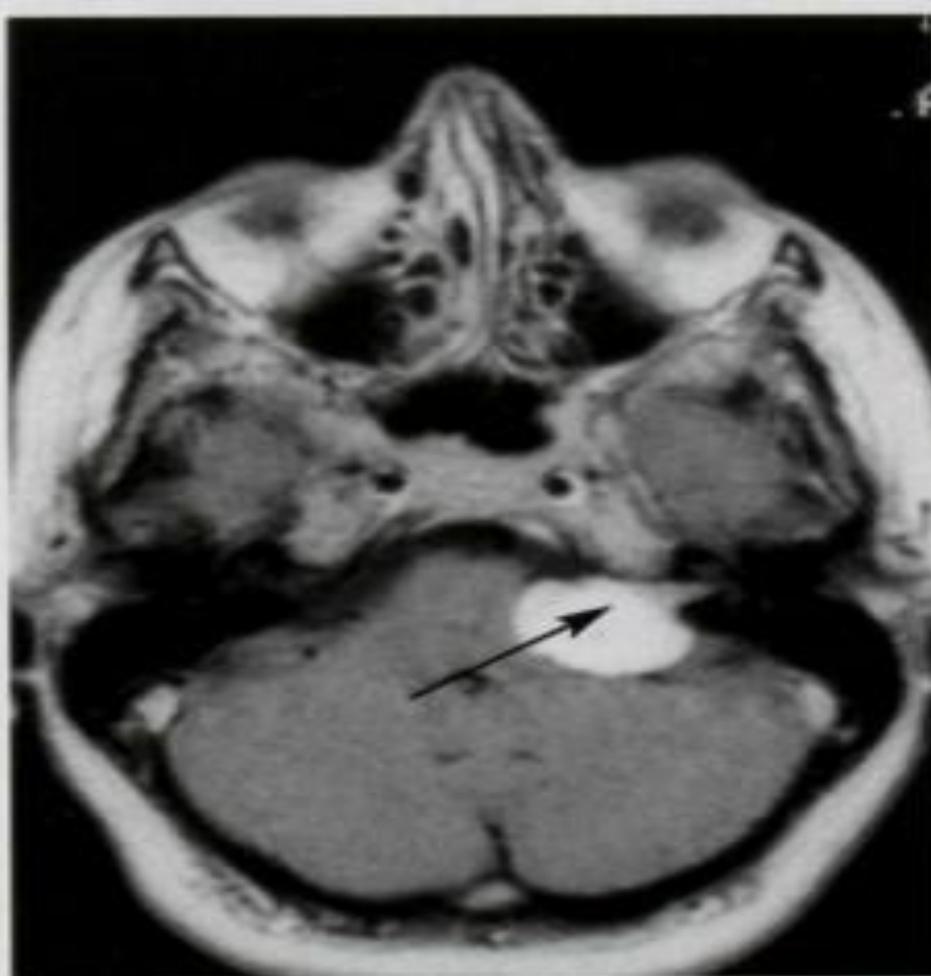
Acoustic neuroma. The most common early presentation of an acoustic neuroma is a unilateral sensorineural hearing loss. An MRI scan is an essential investigation to exclude this tumor in all cases of unilateral sensorineural hearing loss unless there is a certain other cause, e.g., trauma, mumps, meningitis. There is now a ►
